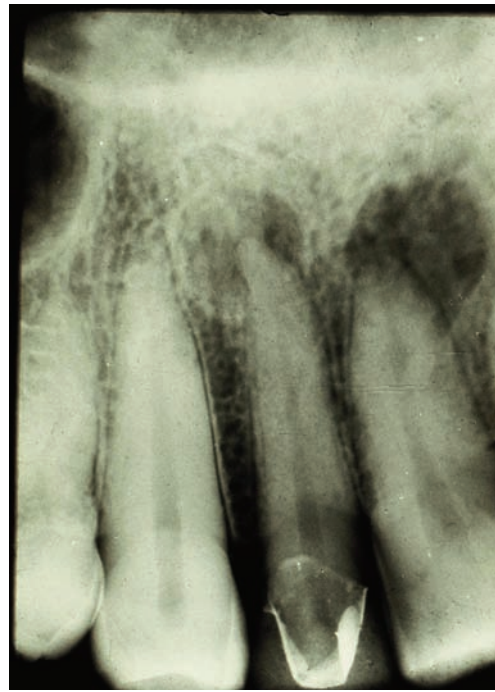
Periapical granuloma. (Courtesy of Dr. John Jacoway.)
